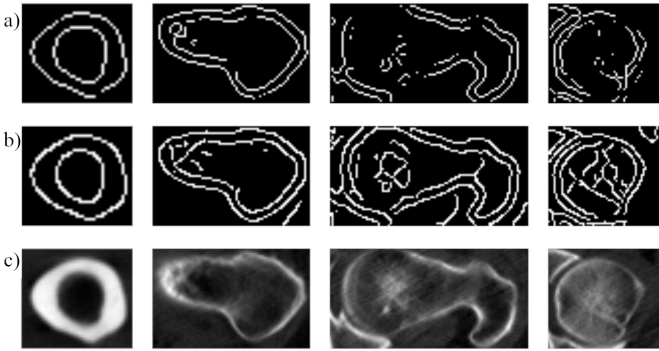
a) LoG edge detection b) Canny edge detection with optimized parameters c) corresponding CT images.
